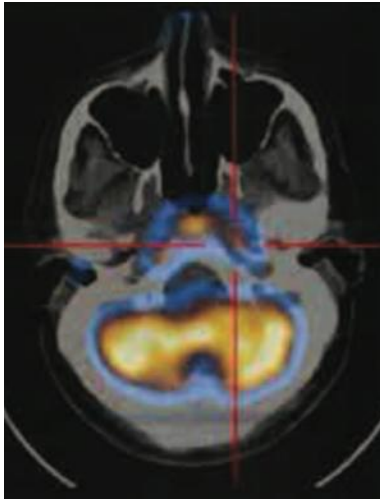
PET-CT with F-18-FDG: glycolytic hypermetabolism on the inferior part of left sphenoid sinus and active osteomyelitis on left clivus (SUV Max on late study= 7);
